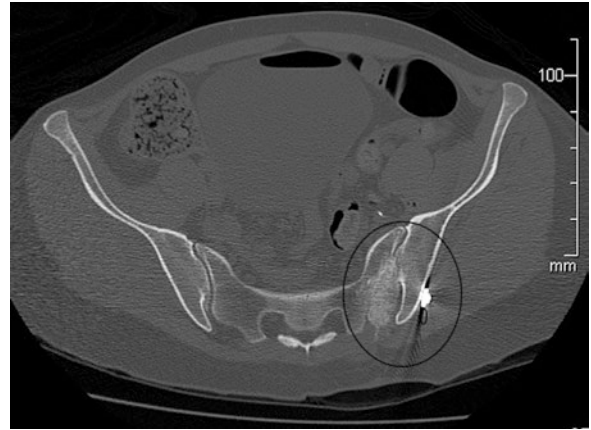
An axial CT with a circle around the bone graft impacted into the sacroiliac joint for fusion
